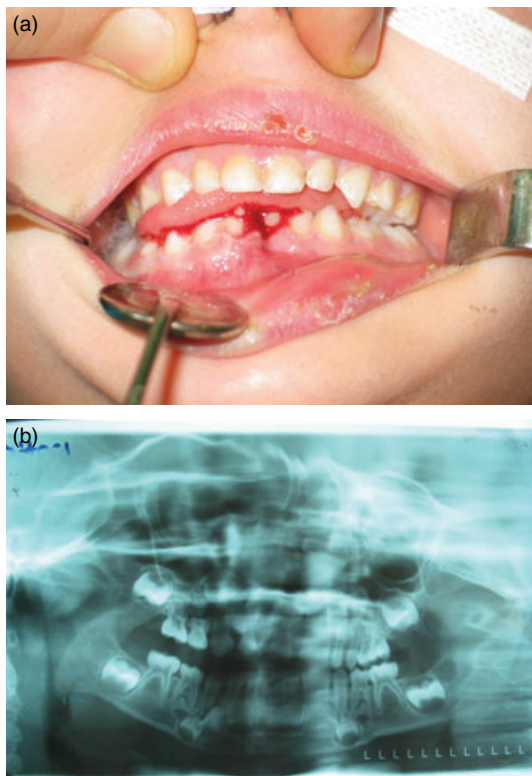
(a) Preoperative intra-oral appearance of the fracture. (b) Preoperative panoramic X-ray of the patient. Note that there is primary occlusal contact at the left mandibular posterior site as a result of medially dislocated left mandibular dento-alveolar structure.
